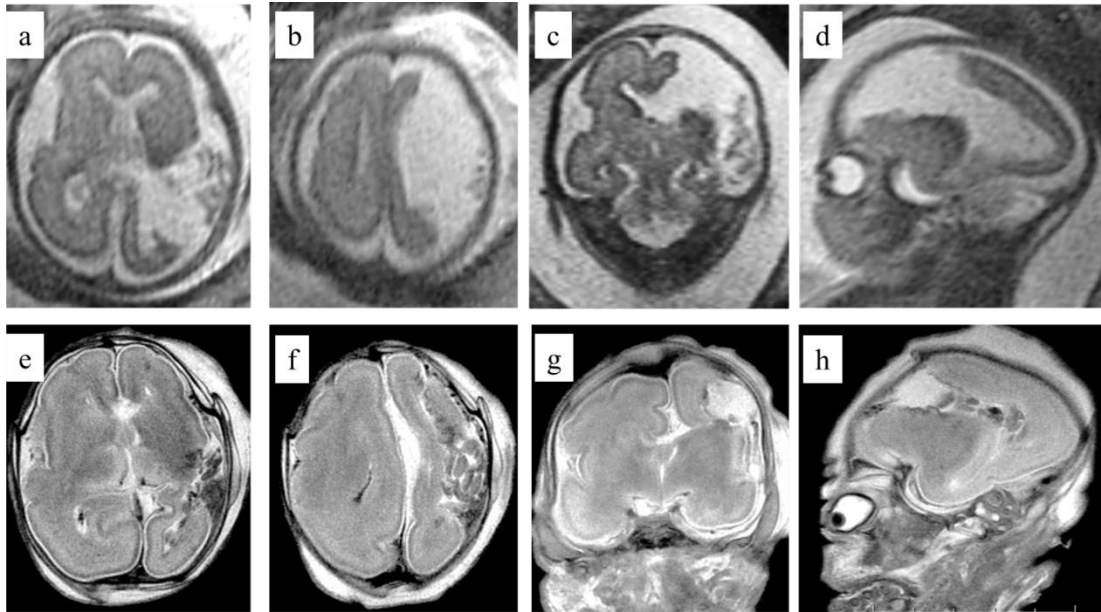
Ischemic stroke. Axial (1a and 1b), Coronal (1c) and parasagittal (1d) T2-weighted images of a 23gw fetus in utero with an arterial infarction of the left cerebral hemisphere involving the posterior division of the middle cerebral artery. There is no definite evidence of haemorrhage on the in-utero MR images but the equivalent T2-weighted images post-mortem MR images (1e-1h) show haemorrhagic transformation.
